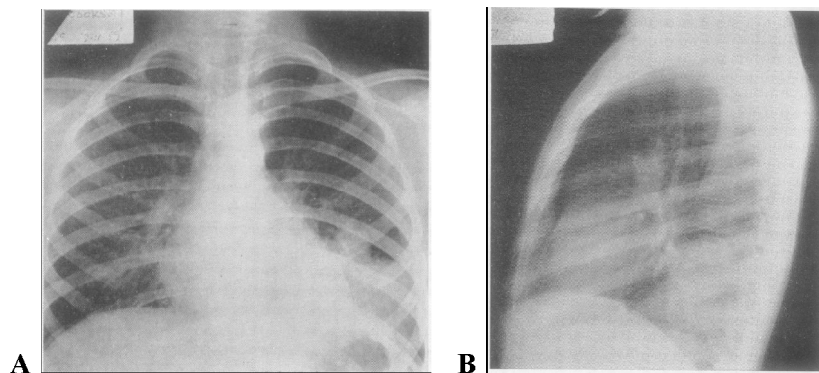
Chest X-ray appearance of an extralobar sequestration (3):
